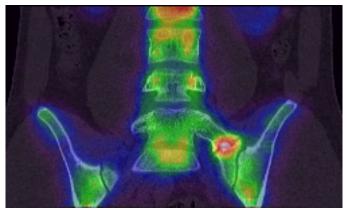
Preoperative: SPECT scan with increased captation at left L5-S1 LSTV.
